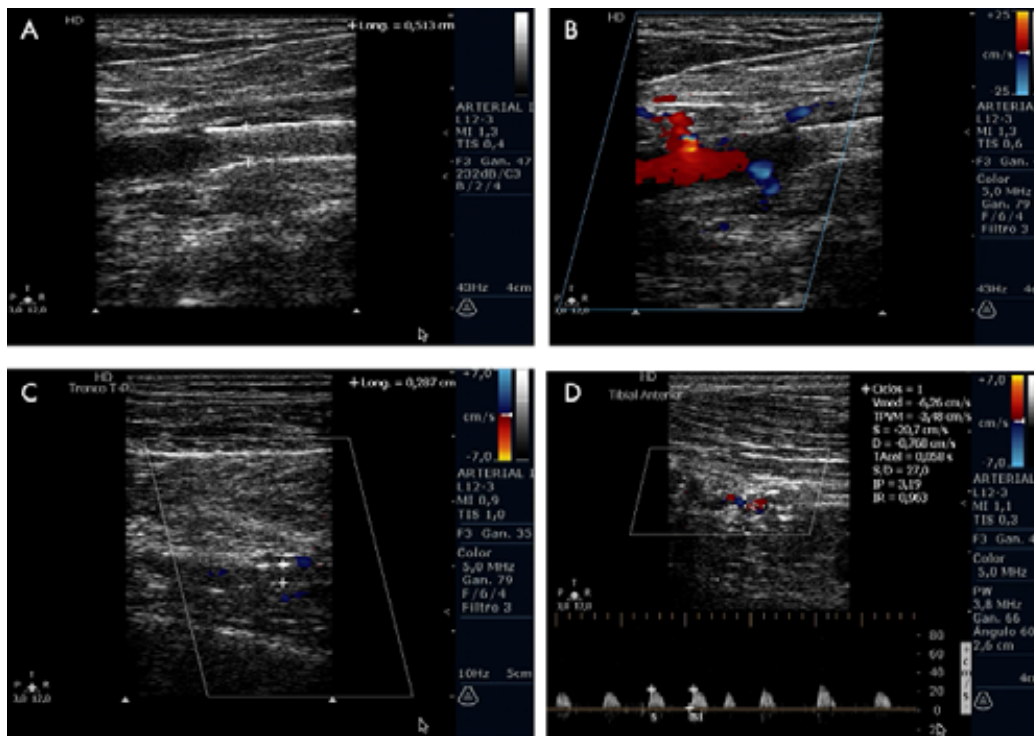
Pre-surgical arterial duplex of the right lower limb. A) proximal segment of stent in popliteal femoral artery blocked by hyperechoic material; B) color Doppler showing stent blockage; C) tibiofibular trunk without arterial flow; D) anterior tibial artery with monophasic flow.
